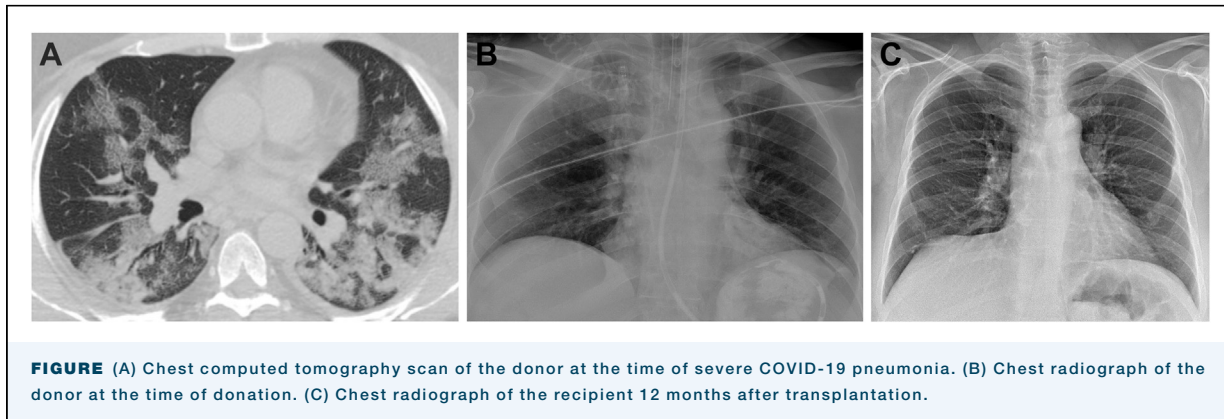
FIGURE (A) Chest computed tomography scan of the donor at the time of severe COVID-19 pneumonia. (B) Chest radiograph of the donor at the time of donation. (C) Chest radiograph of the recipient 12 months after transplantation.
